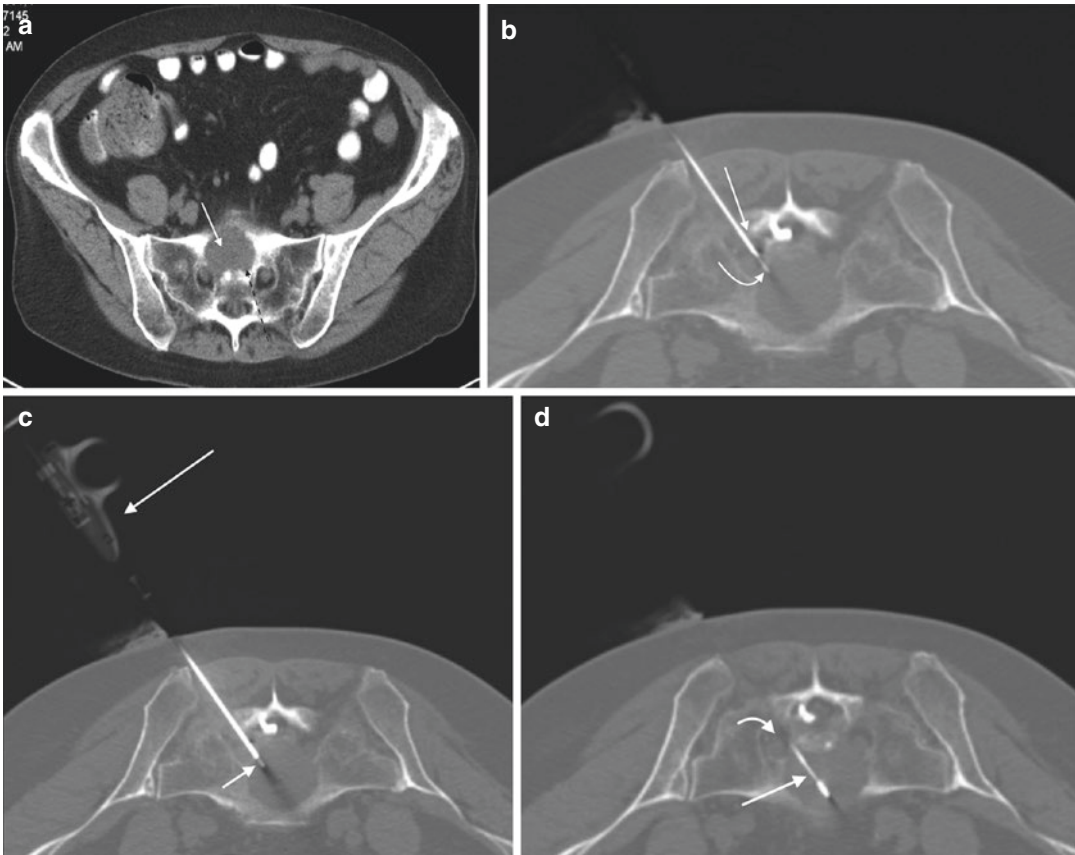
An 81-year-old female with severe low back pain and a lung mass. Axial CT image (a) level of the pelvis shows a round soft tissue mass within the S1 vertebra (arrow); the lesion erodes the anterior aspect of the sacral promontory. This lesion is challenging to access (dashed arrow). Axial CT image (b) shows the use of coaxial technique with advancement of a guide cannula (large arrow) over an insert needle (curved arrow)
